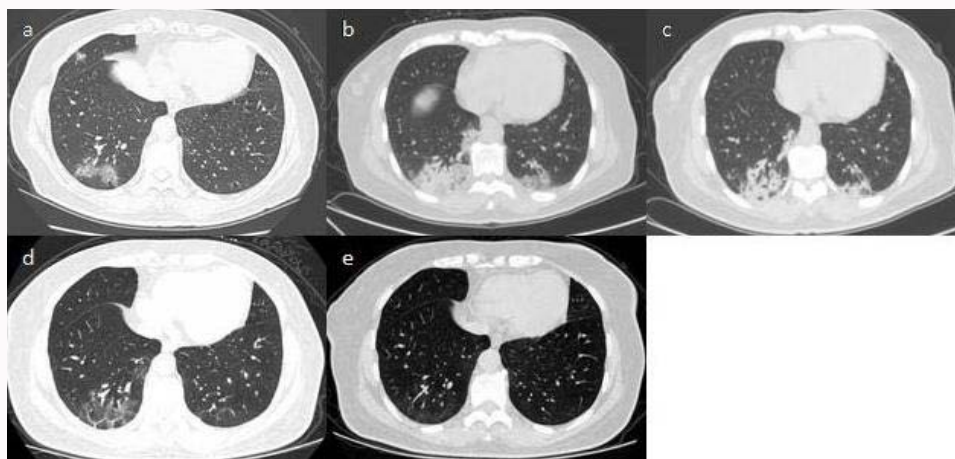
Chest CT images of the 57-year-old woman.
